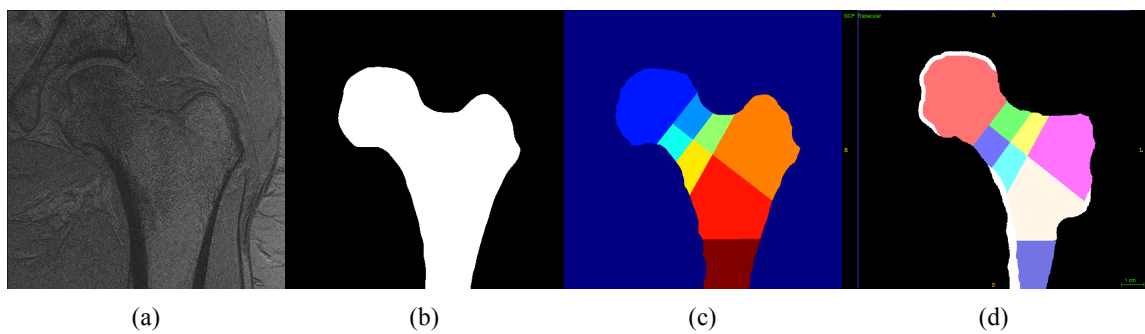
(a). A example slice of human proximal femur from an MRI image. (b). Manual segmented trabecular bone ROI. (c). Manual labeled subregions. (d). An example showing the overlay of segmented subregions using our method over the original ROI.
